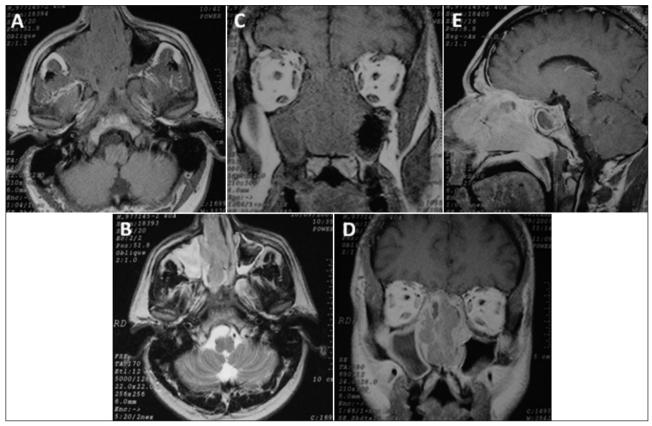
[A] (TI - Weighted MRI, Axial) and [B] (T2-WI) - Expransive solid lesion filling the nasal cavity and right maxillary sinus, isointense in TI WI and T2WI. The left maxillary sinus is lined by T2 hipermintense material suggestive of inflammatory sinusopathy. [C] (TI - Weighted MRI, Coronal) e [D] (after Contrast) - Lesion shows irregular contrast enhancement and extends superiorly into the ethmoidal cells. [E] (TI - Weighted MRI, Sagittal with contrast) - Lesion occupies nasal cavity but appears to have little if any intracranial extension. Frontal and sphenoidal sinuses display mucosal thickening and exudate.
